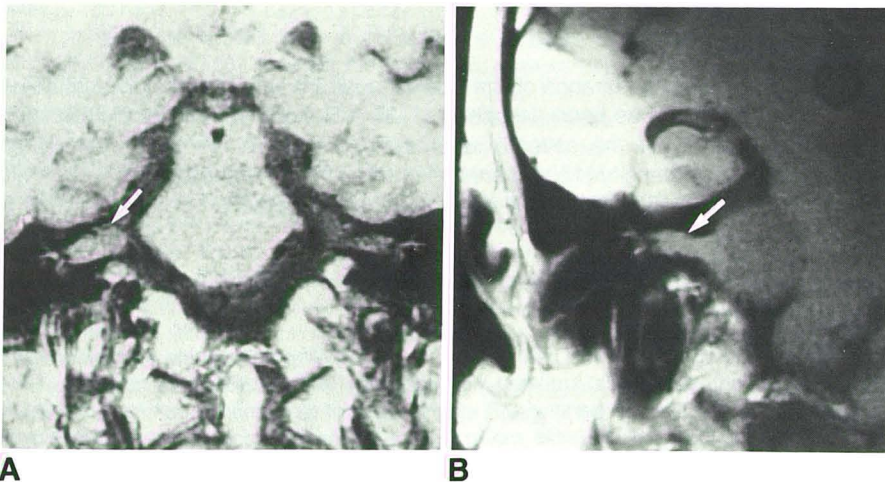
Two examples of acoustic neurinomas having homogeneous intracanalicular signals (arrows) in coronal short TR and TE MR images obtained with head (A) and surface (B) coils. The tumors filled the internal auditory canals at surgery. The homogeneous appearance of the canals is typical of intracanalicular tumor.
